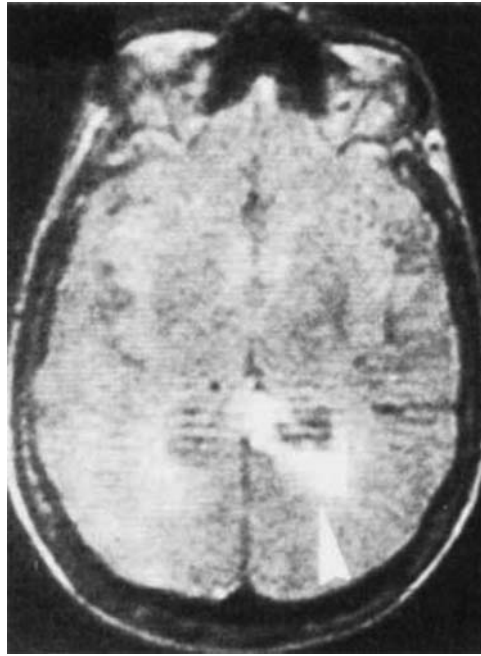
Images of the brain: 1990s. MRI image of one patient with left unilateral spatial neglect after right hemispheric damage: area of abnormally bright signal involving the right occipital paraventricular white matter (white arrowhead) (Vallar et al., 1991, Fig. 1).
